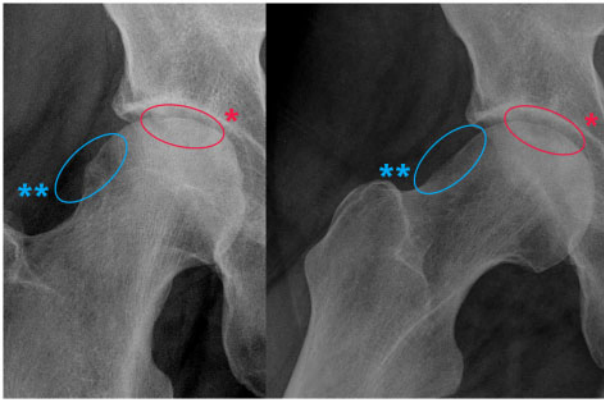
Display detail of pelvis anteroposterior and frog-leg lateral X-ray of the right hip showing *ONFH ARCO III with flattening of the femoral head (red marking) and pathological head-neck offset indicative of cam-type FAI (blue marking) – sample image from the patient collective.
